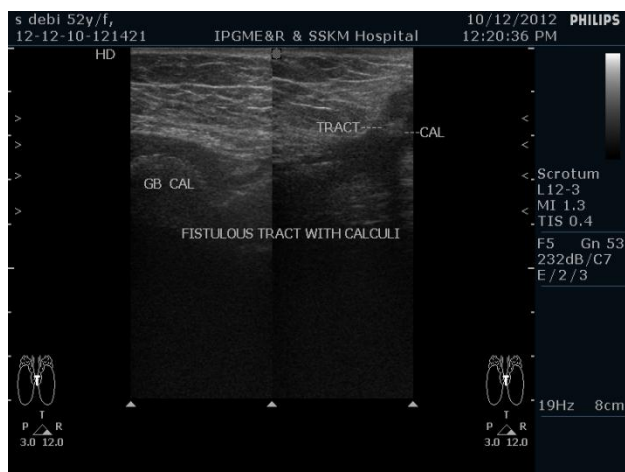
Ultrasonography showing contracted gallbladder packed with stones and a tract communicating with the skin, also containing stones.
